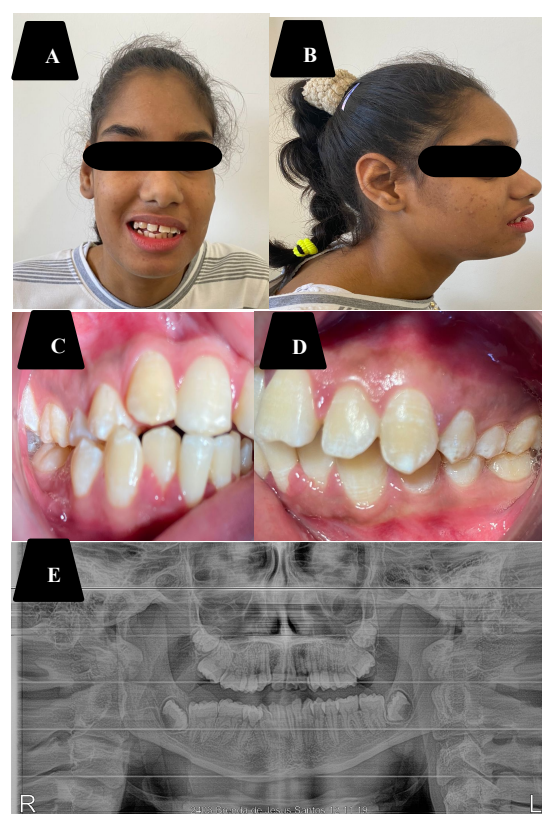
Clinical and radiographic follow-up after two years and three months.
